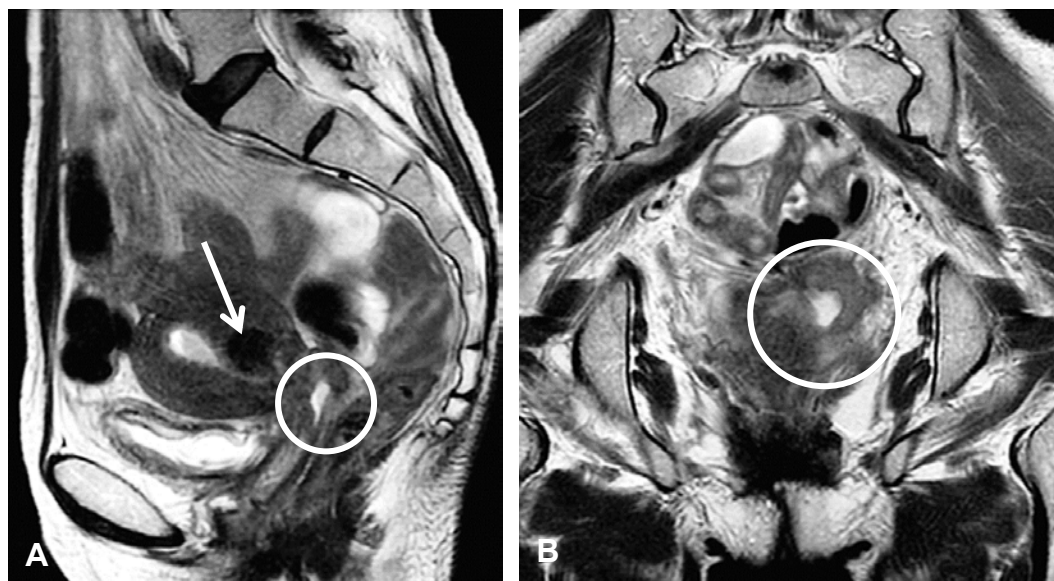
(A) Sagittal and (B) coronal non-fat-suppressed T2-weighted images of a 64-year-old female with a moderate-sized uterine fibroid (arrow) and cervical mass (circles).
